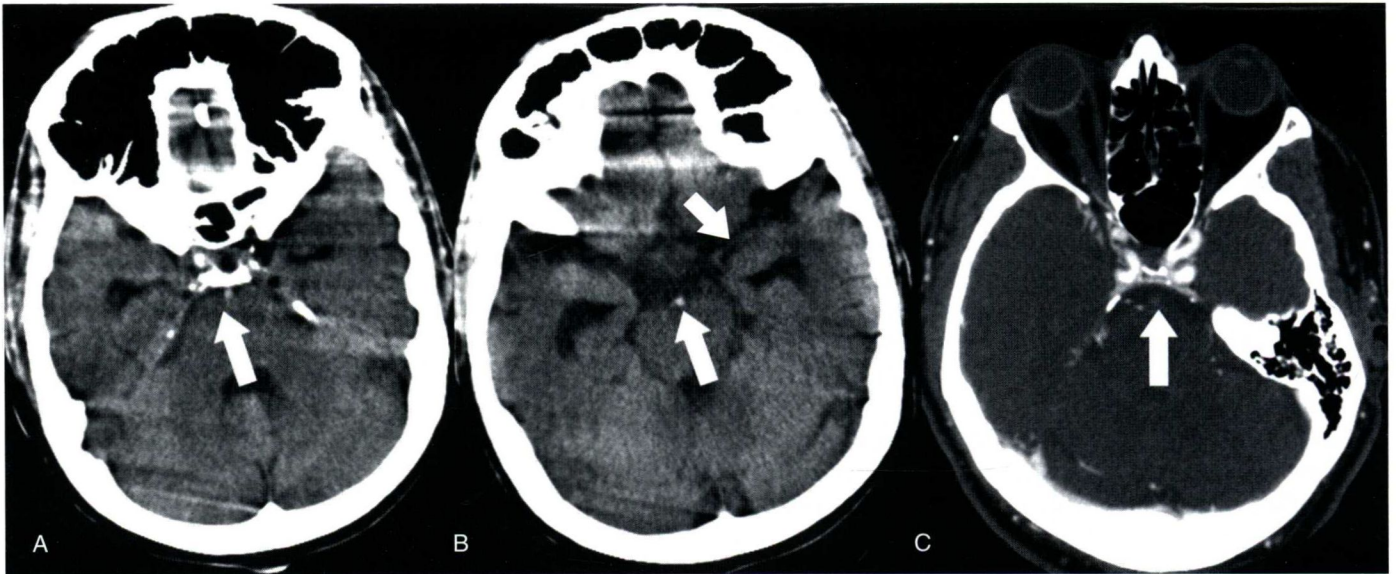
Acute basilar artery thrombosis. (A, B) Axial unenhanced CT images show increased attenuation in the basilar artery (arrows) as compared to the left middle cerebral artery (short arrow), indicating basilar artery thrombosis, in this patient with acute deterioration of neurologic status and alertness. (C) Axial image from a CTA performed shortly after shows lack of contrast filling of the basilar artery (arrow) compared to the carotids.
